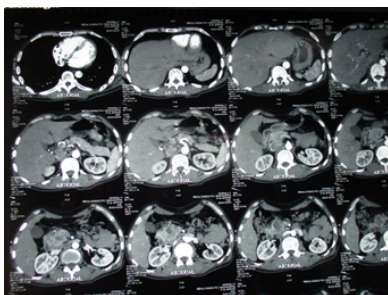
Contrast CT of the abdomen showing the solid-cystic mass in the pancreatic head
